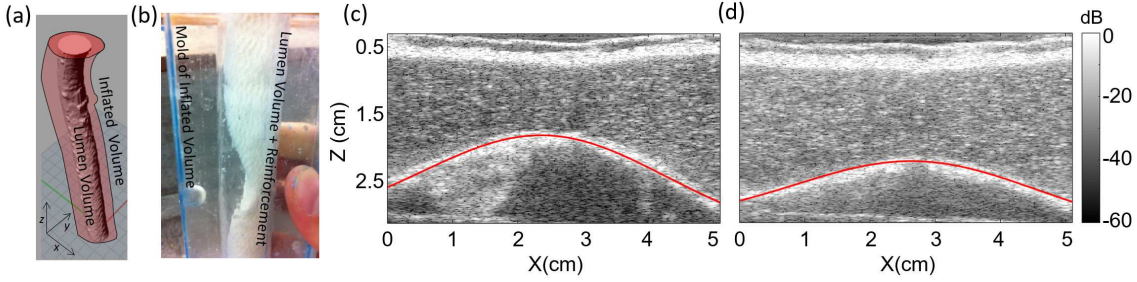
Manufacturing process of the stenotic aortic models. (a) Reconstructed volumes from CT-images: lumen volume in grey and inflated volume in red shadow. (b) Lumen volume wrapped in the reinforcing fabric inside the acrylic mold created from the inflated volume. Cross-sectional B-mode images of the models presenting a (c) 50% and (d) 35% occlusion in diameter. The red full line corresponds to the Gaussian profile used to create the stenosis.
